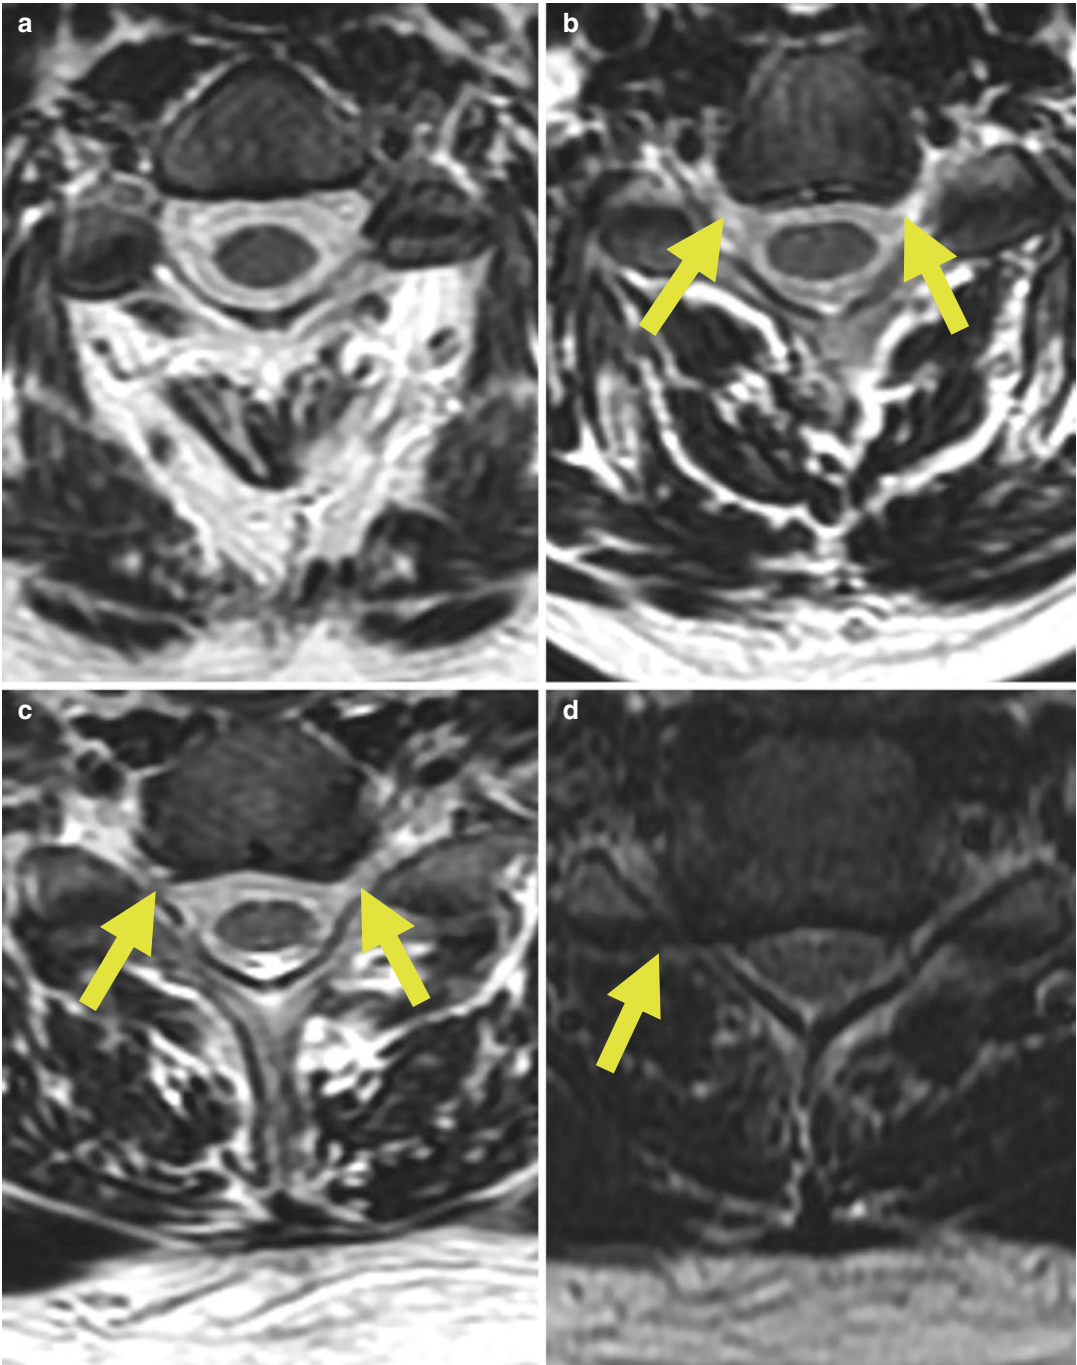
Axial T2-weighted imaging of the cervical spine first demonstrating normal uncovertebral joints (a) which are imperceptible. Mild uncovertebral joint hypertrophy (b) is slightly bulky (arrows), while moderate hypertrophy
